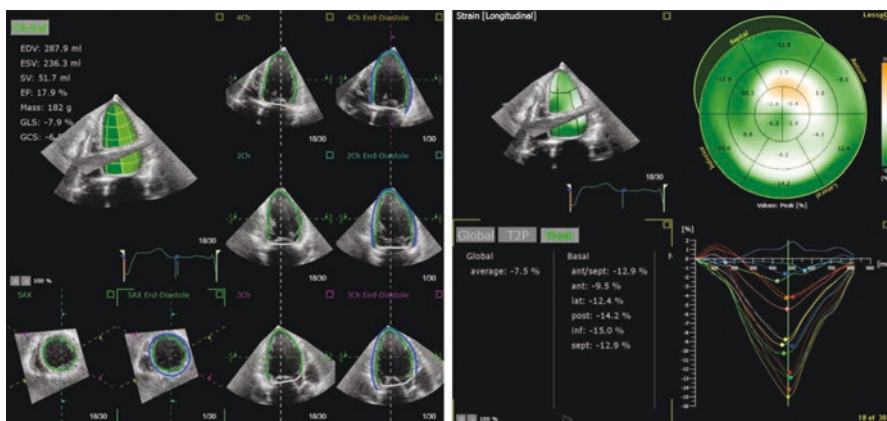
Three-dimensional echocardiography assessment of left ventricular ejection fraction and global longitudinal strain for follow-up of mitral regurgitation
